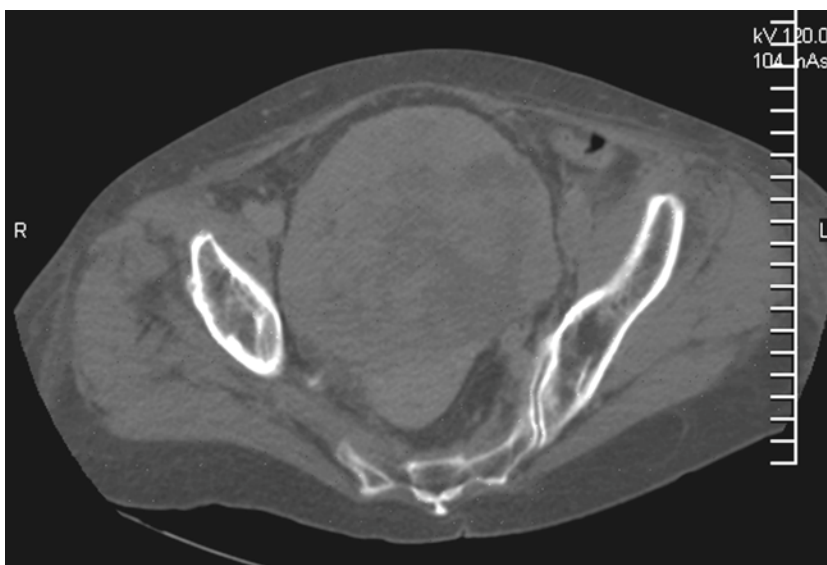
Computed tomography revealed a solid tumor of the urinary bladder, measuring 25 cm in diameter. The uterus was visibly compressed dorsal of the tumor.
